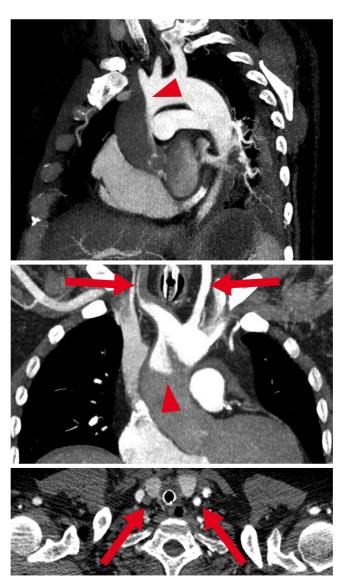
A Watershed phenomenon during VA-ECMO. Computed tomography. Antegrade blood flow (*low contrast*) from the heart competes with retrograde blood flow (*high contrast*) from the ECMO in the aorta, resulting in a watershed phenomenon (*arrowhead*). Here computed tomography of a patient with pulmonary embolism and reduced cardiac output demonstrates a rather proximal watershed, leading to perfusion of the right carotid artery with "heart blood" (*dark*) and the left carotid artery with "ECMO blood" (*bright, arrows*). *Upper panel*: sagittal oblique maximum intensity projection (MIP); *middle panel*: coronal oblique MIP; *lower panel*: transverse plane. (From Napp et al. [36]; © L. C. Napp, C. Kühn, M. M. Hoeper et al. 2015. This publication is an open access publication, available on springer-link.com)
